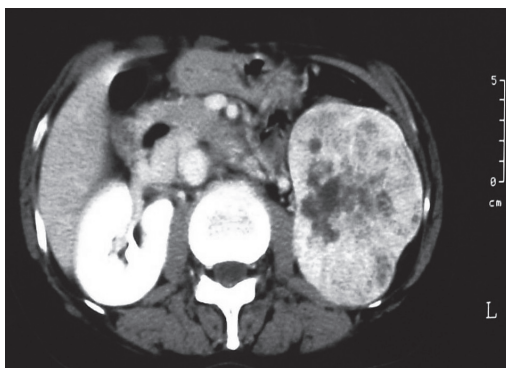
Abdominal CT scan shows a tumor with a diameter of 9 cm at the lower pole of the left kidney.
